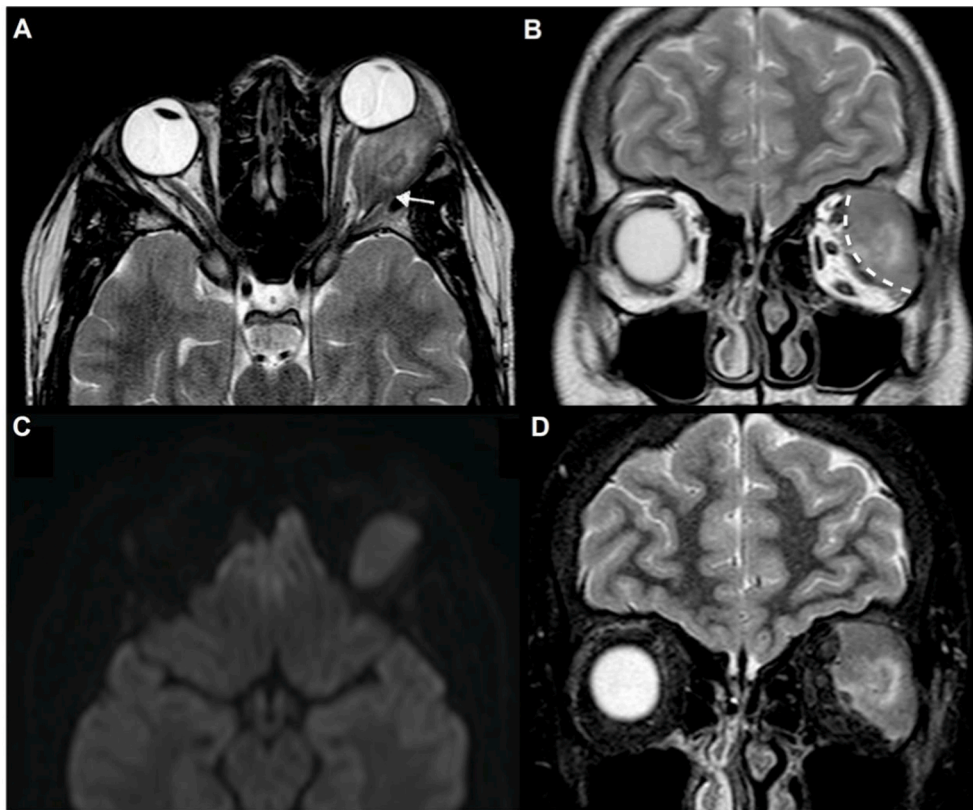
Axial (a) and coronal (b-d) T2w images showing expansive extra-conal orbital lesion arising along the external border of superior and lateral rectus muscles and superior oblique muscle. The lesion presents mild hyperintensity with inhomogeneous core, and slightly restricted water diffusion on DWI (c) indicating hypercellularity. Extra-ocular muscles and optic nerve are displaced (*white dotted line*); marked left eye proptosis is also present. The lesion does not spare lacrimal gland that seems to be infiltrated (*not shown*); bony erosion and invasion of the lateral wall of the orbit are clearly visible (*white arrow*).
